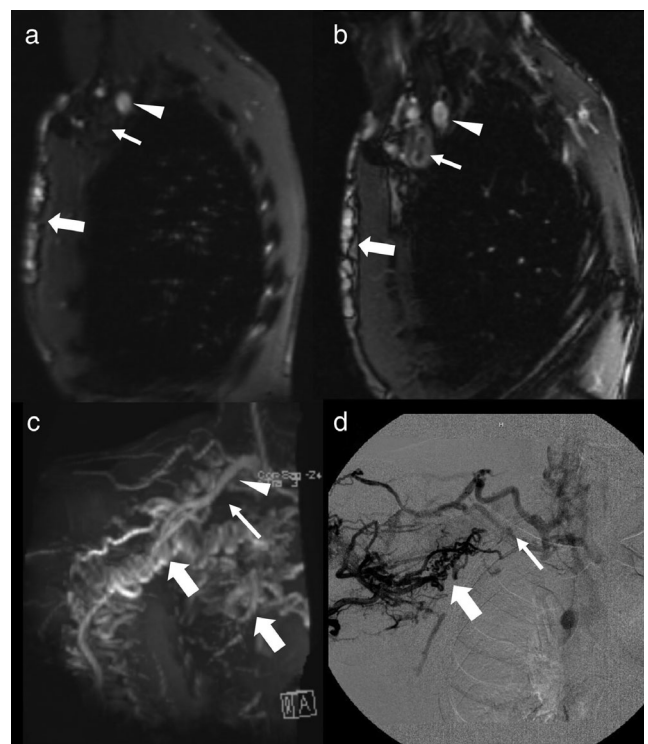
TOF MRA of right subclavian vein occlusion in a 40-year-old man with end-stage renal disease and a right arm arteriovenous fistula. Sagittal TOF MR angiographic image (a) demonstrates a lack of flow in the right subclavian vein (thin arrow), just inferior to the right subclavian artery, which is patent (arrowhead). Multiple enlarged venous collateral vessels are noted along the right anterior chest (thick arrows). Corresponding sagittal bSSFP MR image (b) shows heterogeneous signal within an expanded right subclavian vein (thin arrow), consistent with thrombosis. Coronal MIP TOF MRA image (c) again shows a lack of flow in the expected location of the right subclavian vein (thin arrow) and multiple venous collateral vessels (thick arrows). These findings were confirmed with catheter venography (d).
